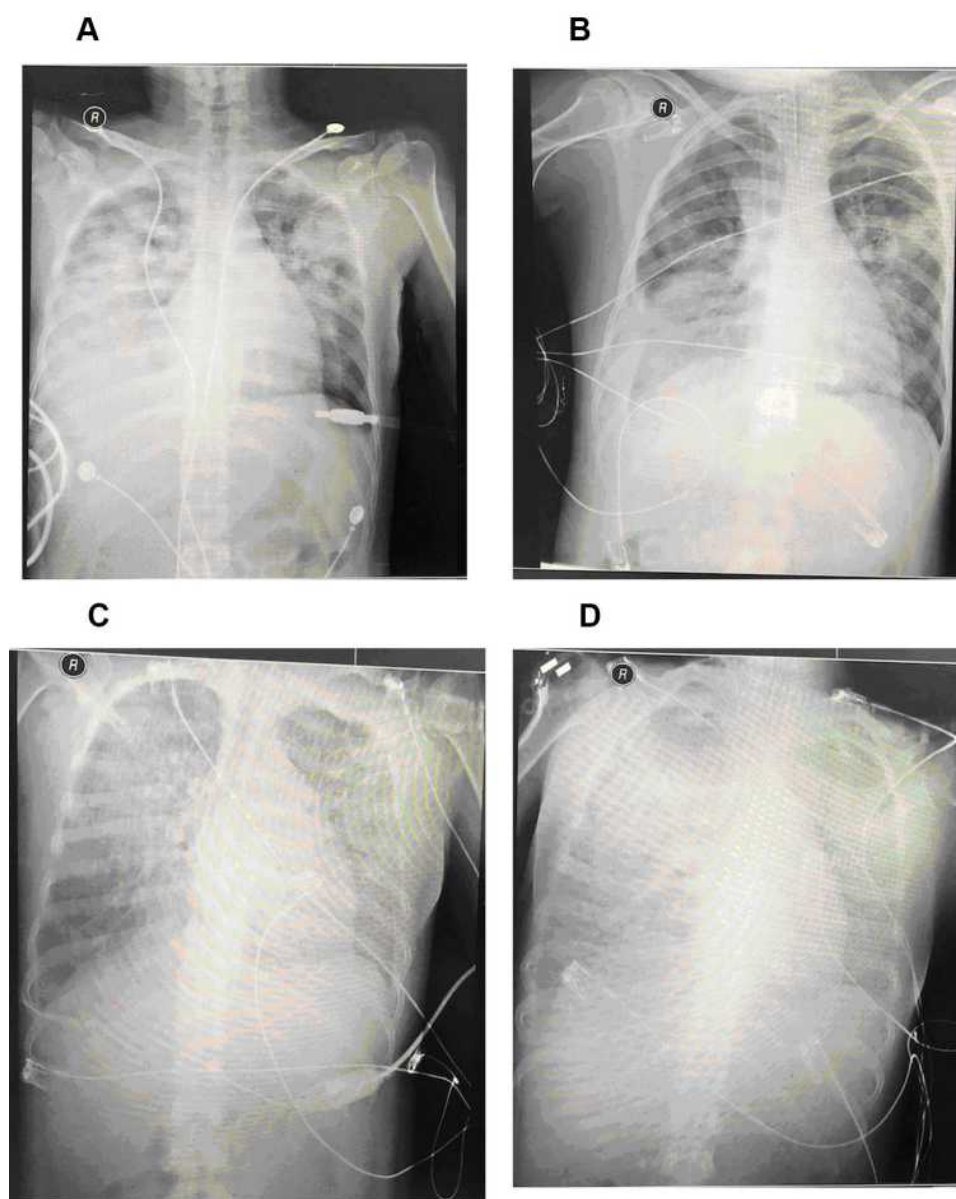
Chest X-ray of a 36-year-old pregnant female patient with *C. psittaci* pneumonia and died of septic shock, DIC, and multiple organ failure. (A) on the first day of hospitalization, (B) on the third day of hospitalization, (C) on the sixth day of hospitalization, (D) on the seventh day of hospitalization.
